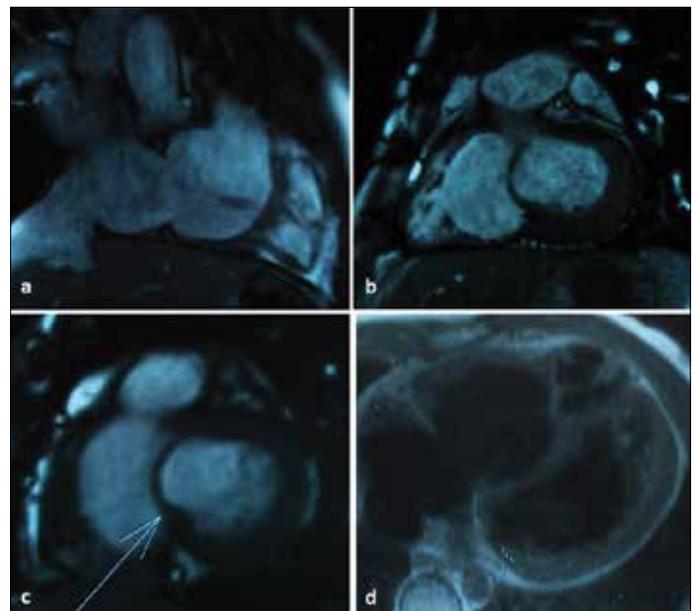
Cardiac MRI demonstrating anomalous muscle bundle dividing right ventricle into proximal and distal chambers (a, d), and membranous interventricular septal aneurysm (b, c)
